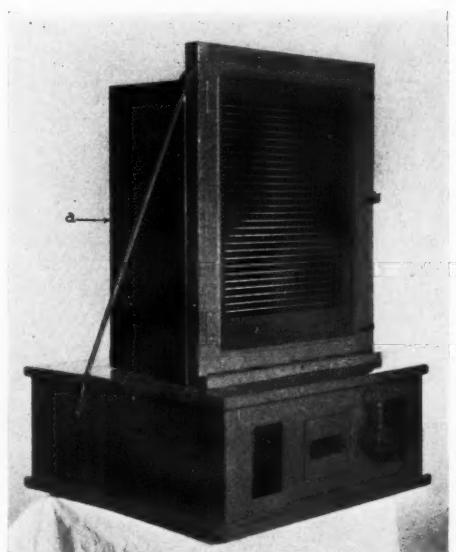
Roentgen kymoscope with the grid door closed and illuminating box (a) in place.
